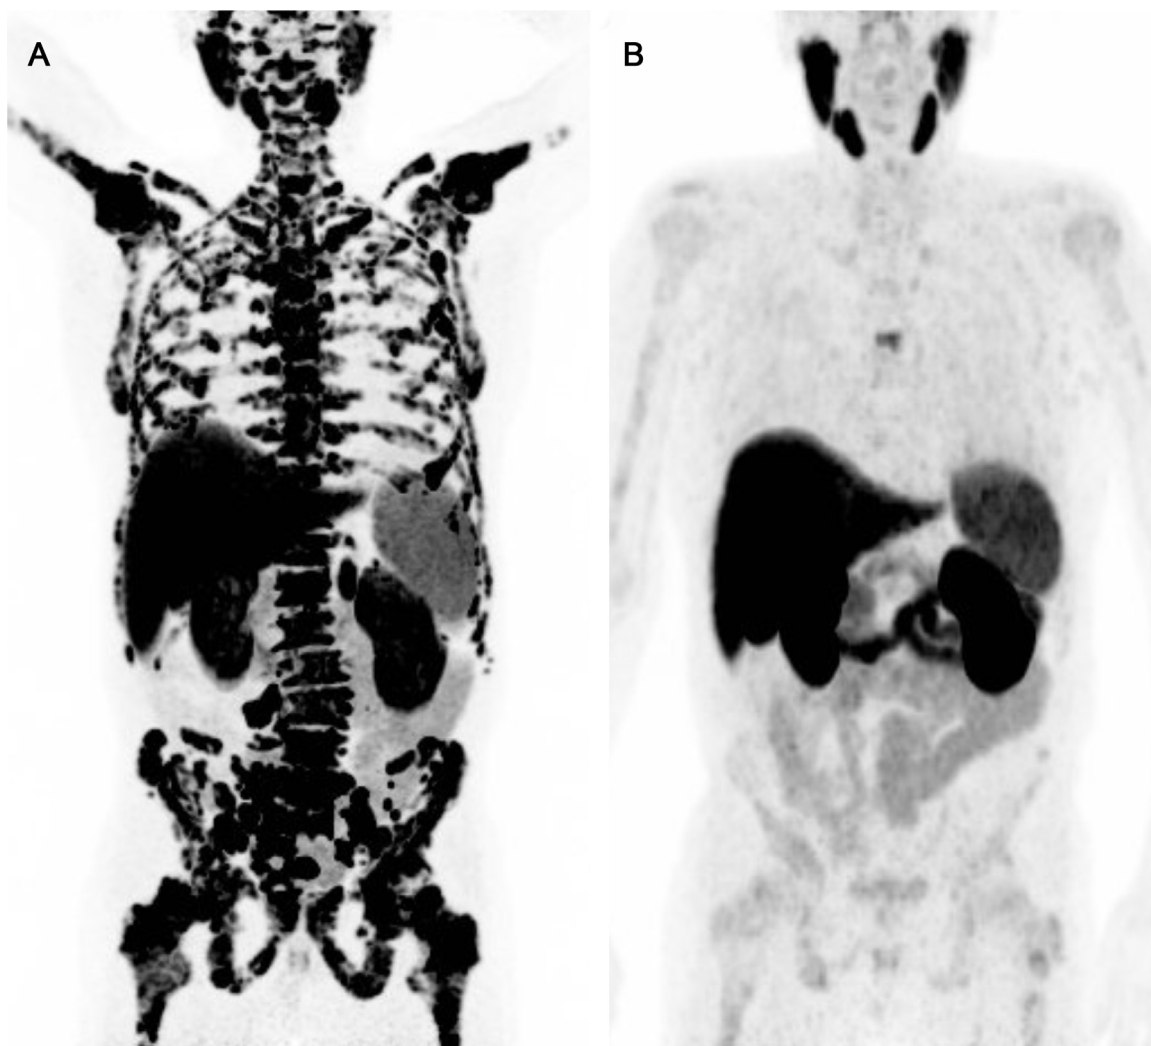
The 73 y/o patient with a spectacular partial response to two cycles of Lu-PSMA. ^{18}F -PSMA-PET/CT demonstrates the tumor load before (A) and one month after the second cycle (B). During that time PSA dropped from 121 ng/ml to 1.3 ng/ml.
